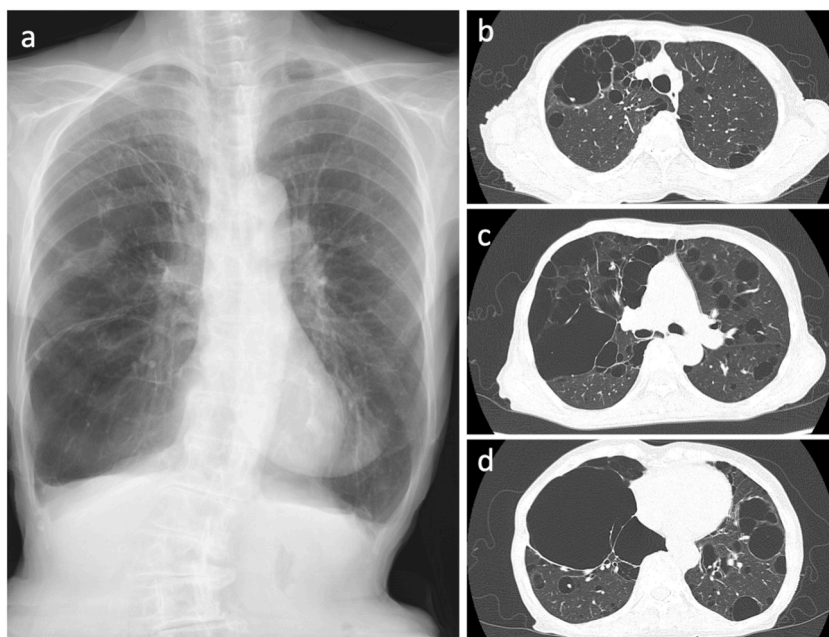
Chest X-ray (a) and high-resolution CT images (b-d) of the patient.
